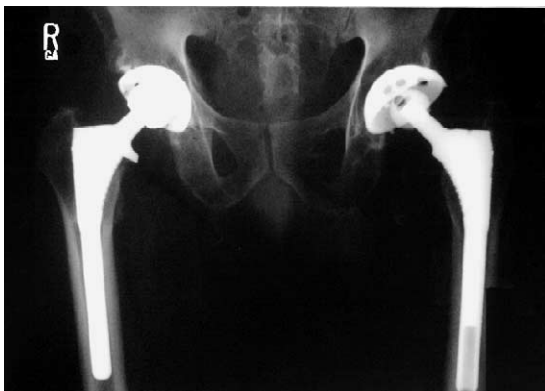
Case 1. Anteroposterior pelvis radiograph 12 months postrevision of right hip, demonstrating 32-mm zirconium ceramic head mating with polyethylene acetabular insert. Intraoperatively, at the time of revision, both the femoral and acetabular components were tested and found to be well fixed.
